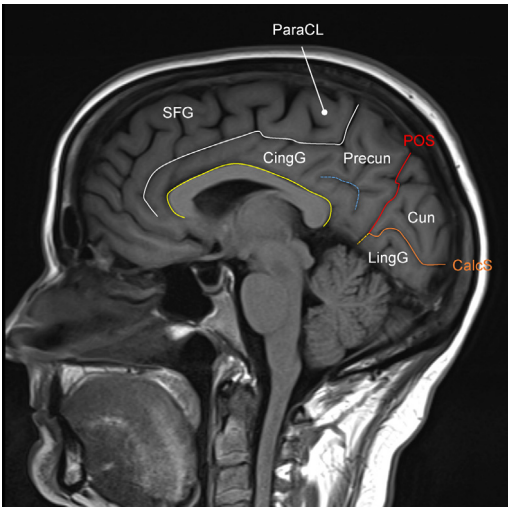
Sagittal T1-weighted image demonstrating key gyri and sulci identifiable along the midline. Labeled gyri include the superior frontal gyrus (SFG), paracentral lobule (ParaCL), cingulate gyrus (CingG), precuneus (Precun), cuneus (Cun), and lingual gyrus (LingG). Outlined sulci include the cingulate sulcus (white line), callosal sulcus (yellow line), subparietal sulcus (blue line), parieto-occipital sulcus (red line, POS), and calcarine sulcus (orange line, CalcS).
